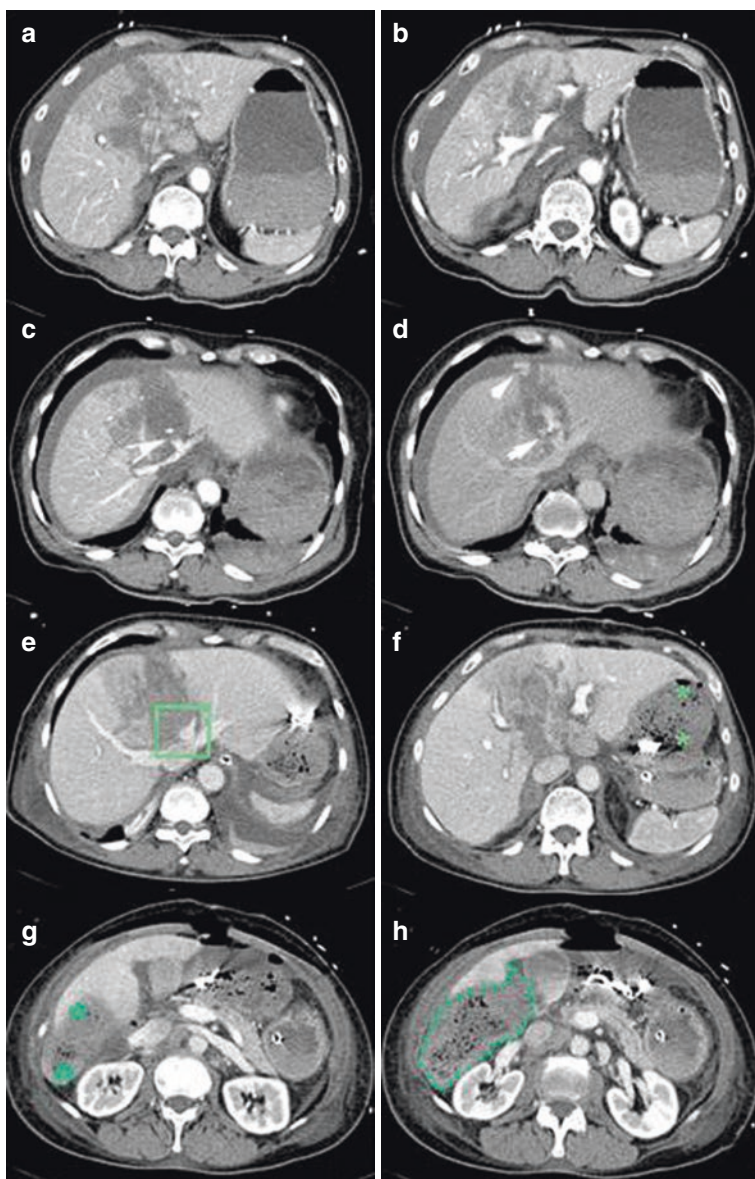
Ski accident in a 62-year-old hemodynamically stable woman. CT shows grade IV liver injuries and absence of vascular extravasation on the arterial and portal acquisition phases (a, b). There is important blood leakage from the middle suprahepatic vein on the late acquisition phase and intraperitoneal blood leakage (c, d). Hemodynamic deterioration during the procedure prompted immediate damage control laparotomy with “blind” PHP positioning. CT performed 2 days later shows bleeding cessation (e); subhepatic pads press the stomach and “wrinkle” the left liver lobe (f); on the right side it is almost exclusively under the liver and pushing on the kidney (g, h)
